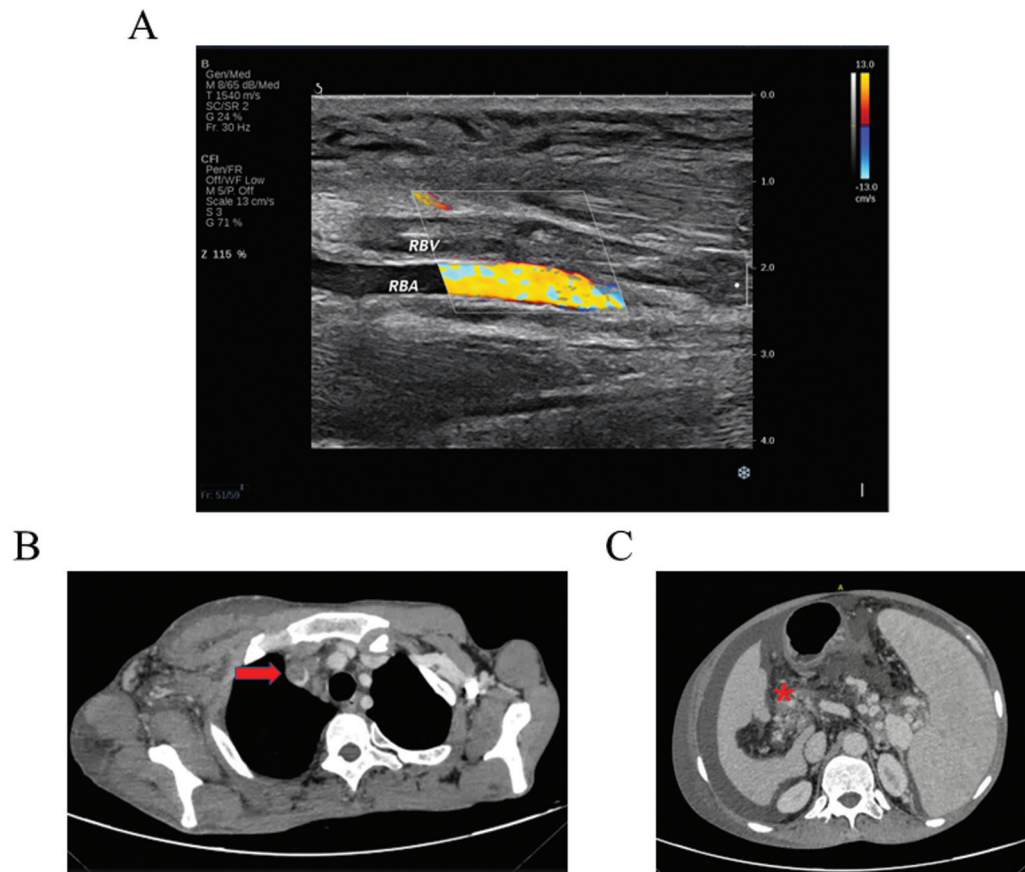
Imaging findings of the proband. (A) Doppler ultrasound showed a solid long hypoechoic mass filling the right axillary and brachial veins. (B) Multi-slice computed tomography showed thrombus extending to the innominate vein (red arrow). (C) Computed tomography revealed cavernous transformation of portal vein secondary to portal vein thrombosis (red asterisk).
